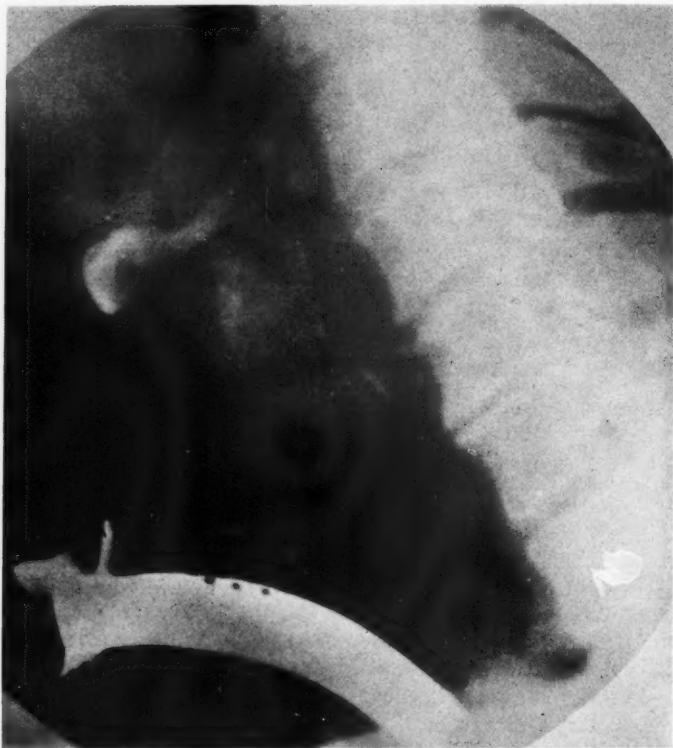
Case 7. Very extensive carcinoma of larynx, recurrent post-operative. Tumor extends from base of tongue down to 2 cm. below the vocal cords. Note that the vertical extent of the tumor can best be shown by roentgen examination. This tumor shrank over 50 per cent following roentgen therapy, showing the surprisingly good palliation achievable in some advanced cases.
